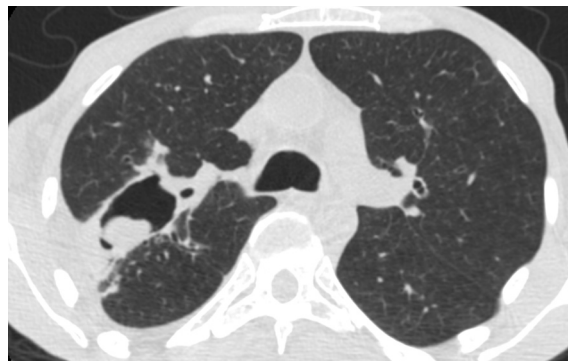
CT Scan from a patient with pulmonary aspergilloma.
